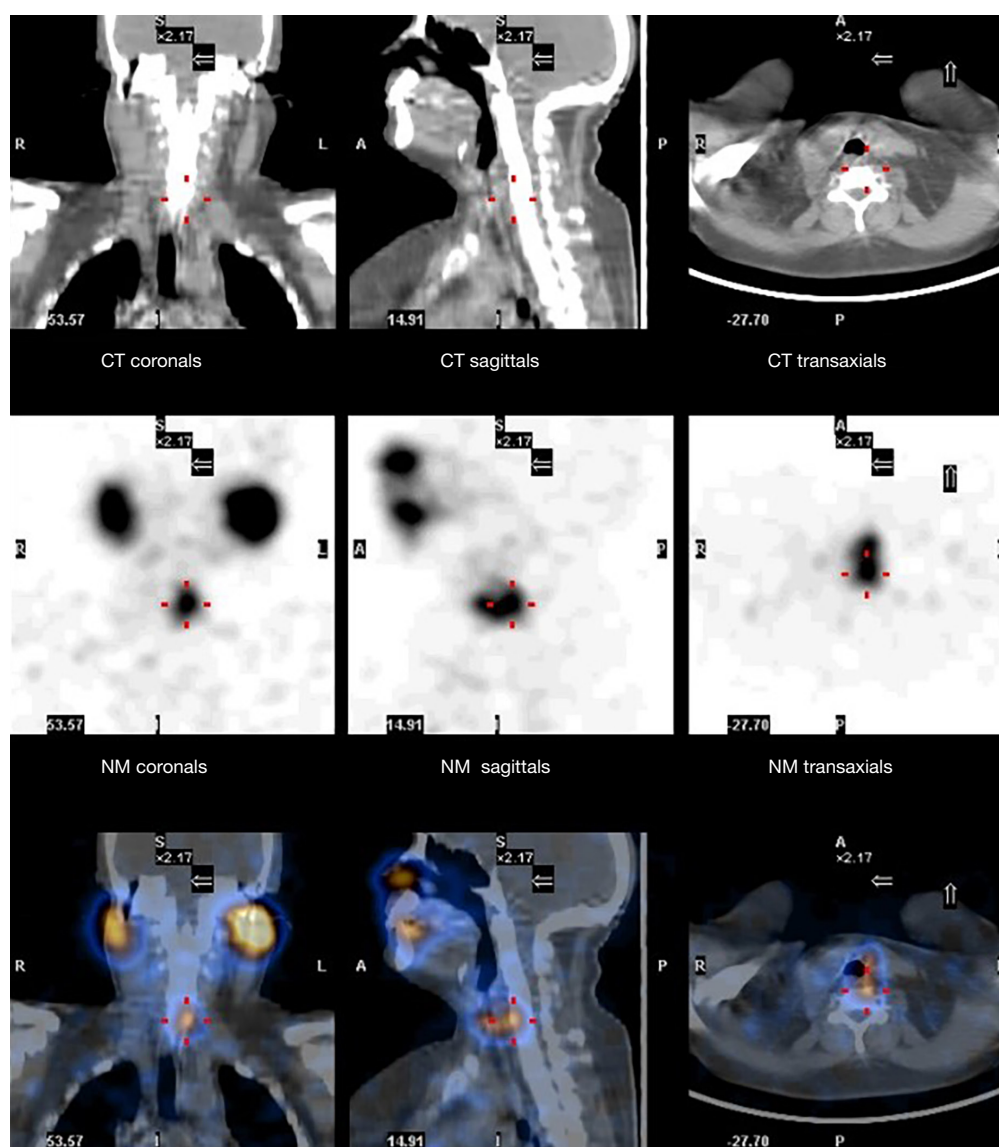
The SPECT/CT images correspond to a screenshot of the workstation, in the coronal, sagittal and transaxial planes. The last line represents the hybrid union between the CT images of the first line and the gammagraphy of the second line. Thus, we obtain qualitative information on the exact anatomical location of the thyroid remnants, close to the surgical bed, and it allows us to differentiate them from the natural accumulation of the isotope in other anatomical places, such as in this case, the salivary glands. A, axial plane; CT, computed tomography; L, left; NM, Nuclear Medicine; P, posterior plane; R, right; S, sagittal plane; SPECT, single-photon emission computed tomography.
